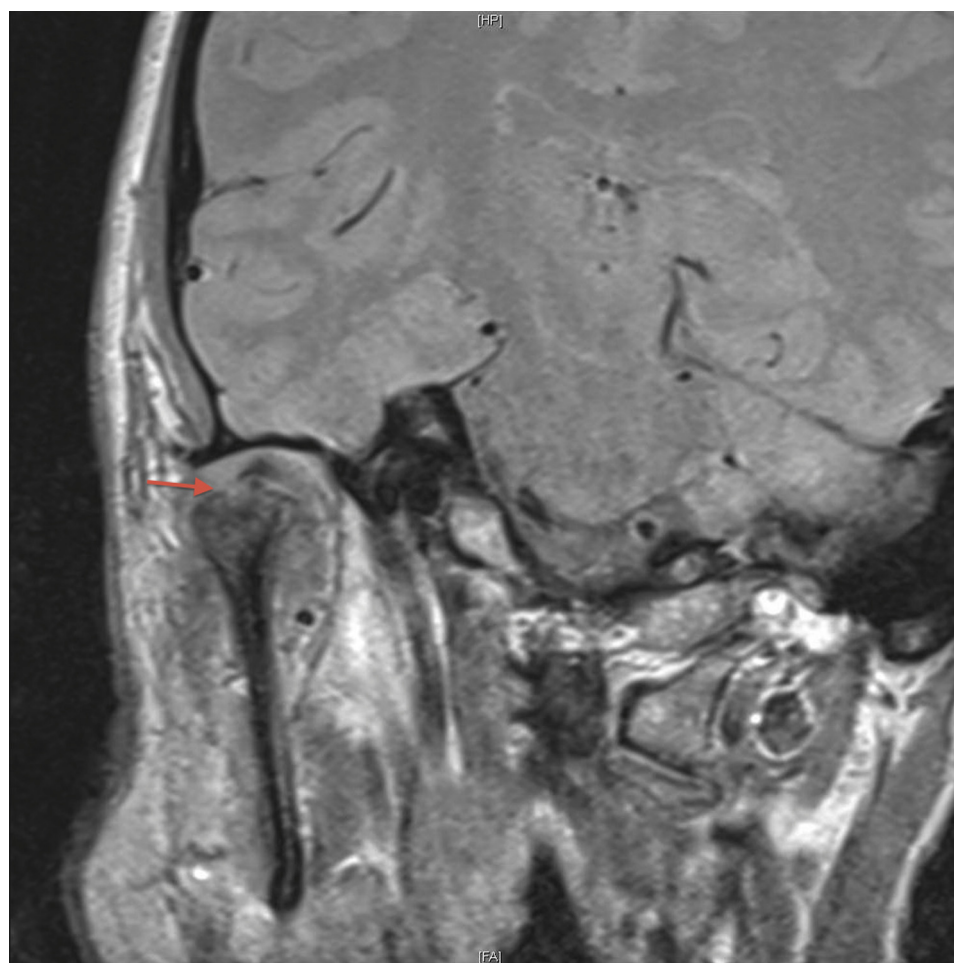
Case 2. Maxillofacial contrast-enhanced T1-weighted magnetic resonance image on day 141 shows osteoarthritic changes (bony erosion and inferior subluxation of the condylar head and medial dislocation of the temporomandibular joint disc) (arrow).
